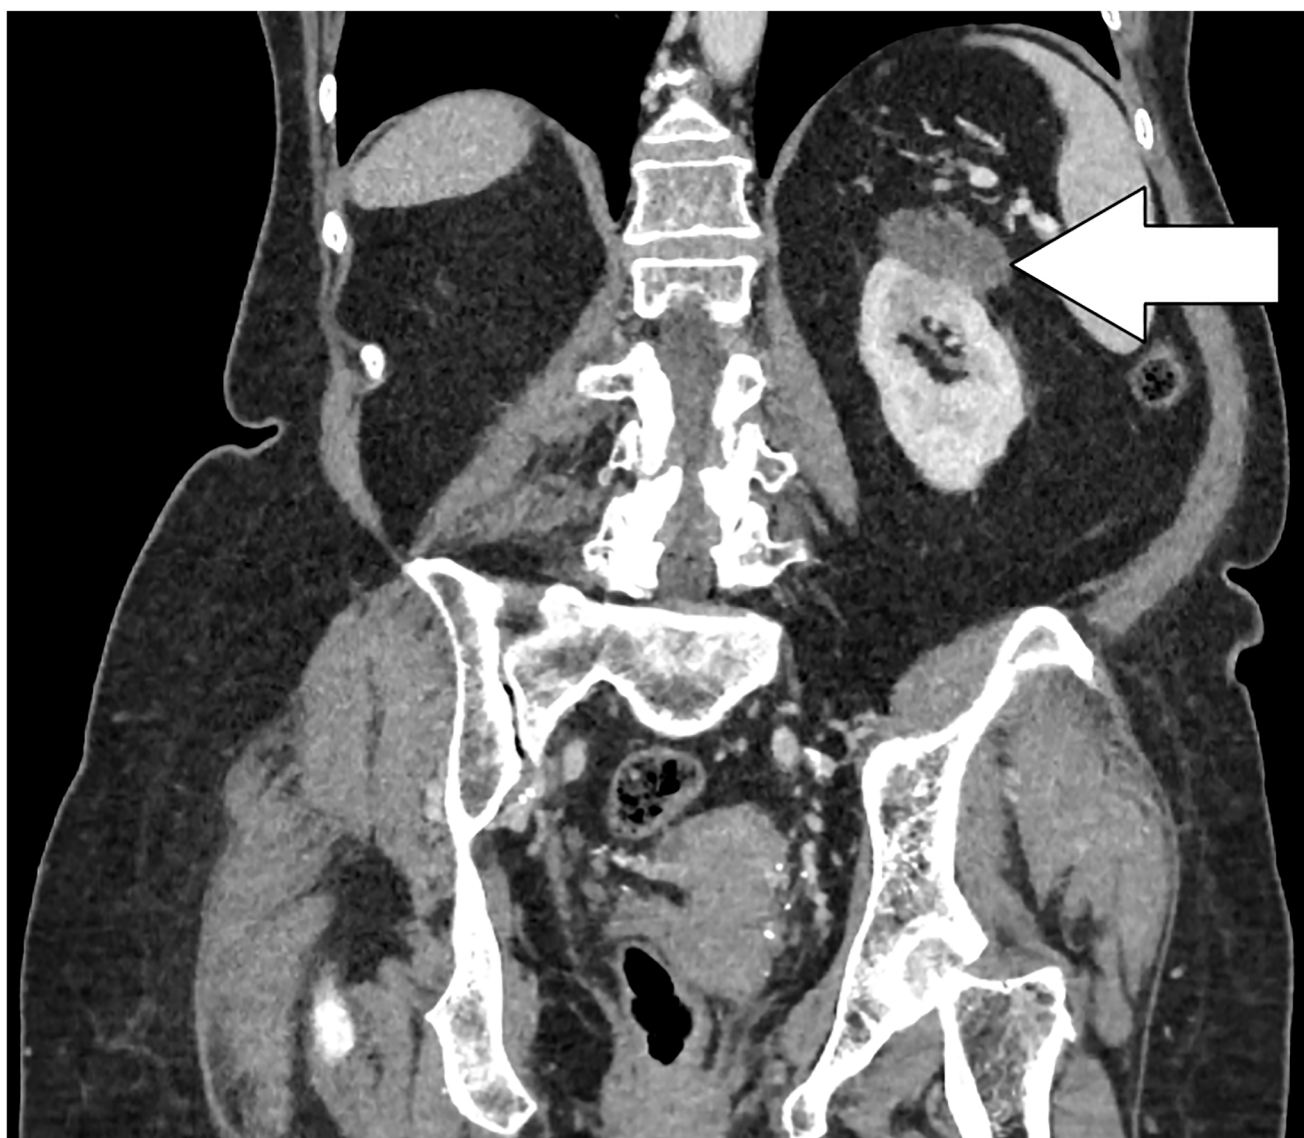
Coronal CT scan of the abdomen with intravenous contrast demonstrating a hypodense lesion measuring 55 × 34 mm arising from the upper of the left kidney.
